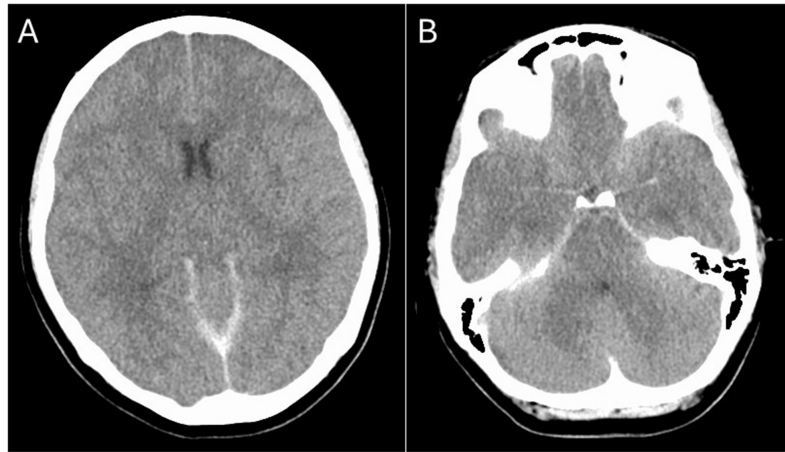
Diffuse cerebral edema on CT head. A-B, Axial sequences at different levels showing loss of gray-white differentiation ((A), (B)) and pseudosubarachnoid hemorrhage (B).
